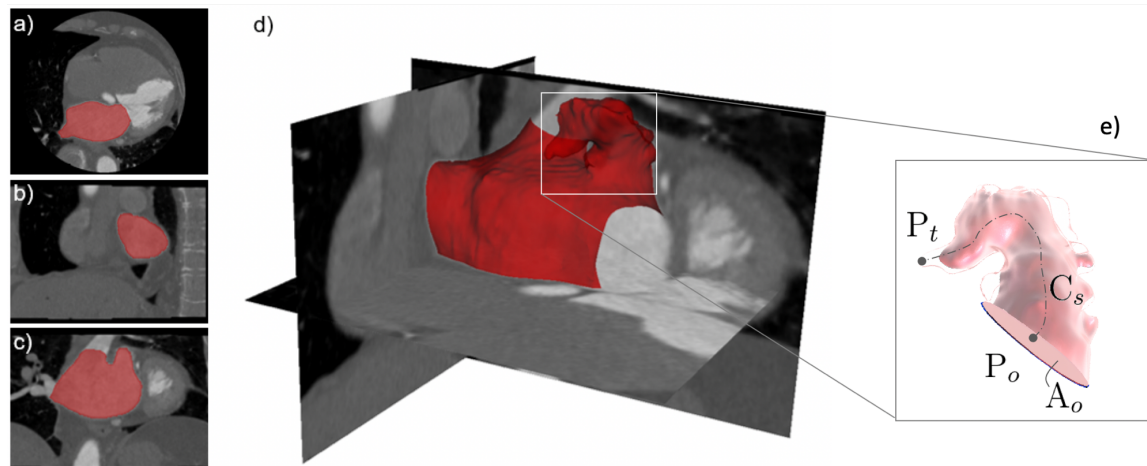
Example of volumetric CT segmentation with axial (a), sagittal (b) and coronal (c) planes and resulted 3D model (d). Identification of the area of the ostium (A_o) and of the centerline $C(s)$ from P_o , where P_t (e).
